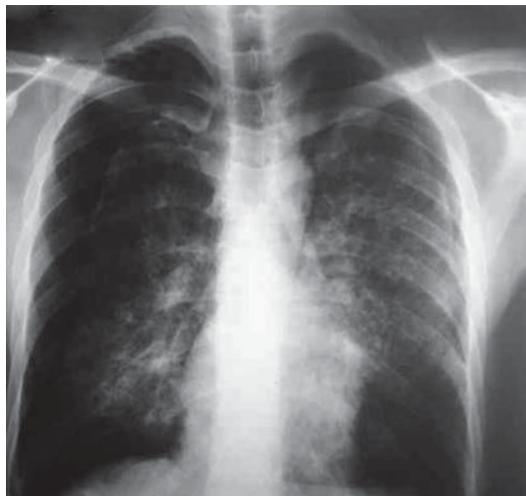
Chest X-ray revealing diffuse, heterogeneous opacities and bilateral pneumothorax. "BJP" e "080208" por "020808".
